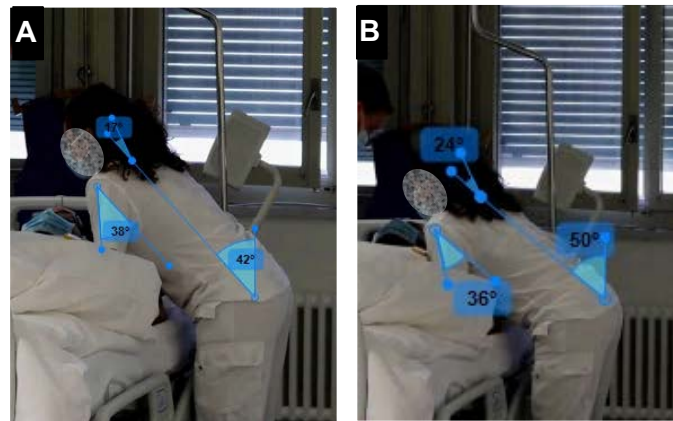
“Not acceptable” postures assumed by the shorter radiographers (helper) during bedside chest X-ray examination in scenario 1: a) during the preparation to position the detector under the patient's back; b) during the preparation to remove the detector from under the patient's back.
